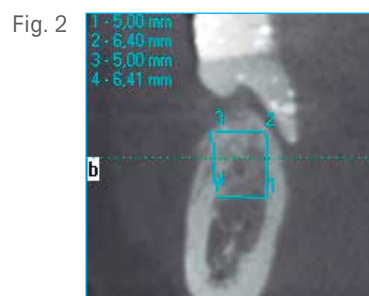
Cone Bean CT scan after the bone augmentation. The implant site width now allows for the placement of a 5 mm diameter implant.
